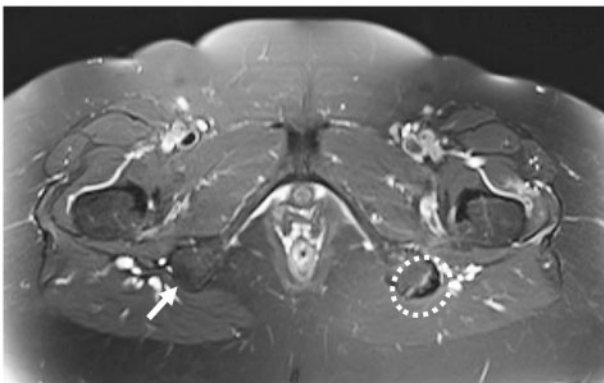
Axial MRI with T2 sequence showing complete avulsion of the right proximal hamstring with edema (full white arrow) and the contralateral normal hamstring origin (dashed white circle)
